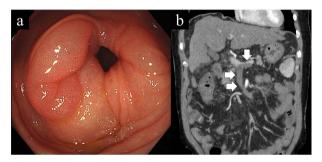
a. Colonoscopy revealed an extremely edematous ileocecal valve and mild edema throughout the colon. 1b. Computed tomography with contrast revealed portomesenteric venous thrombosis (arrows) extending from the umbilical portion of the left portal vein to the splenic and superior mesenteric veins.
